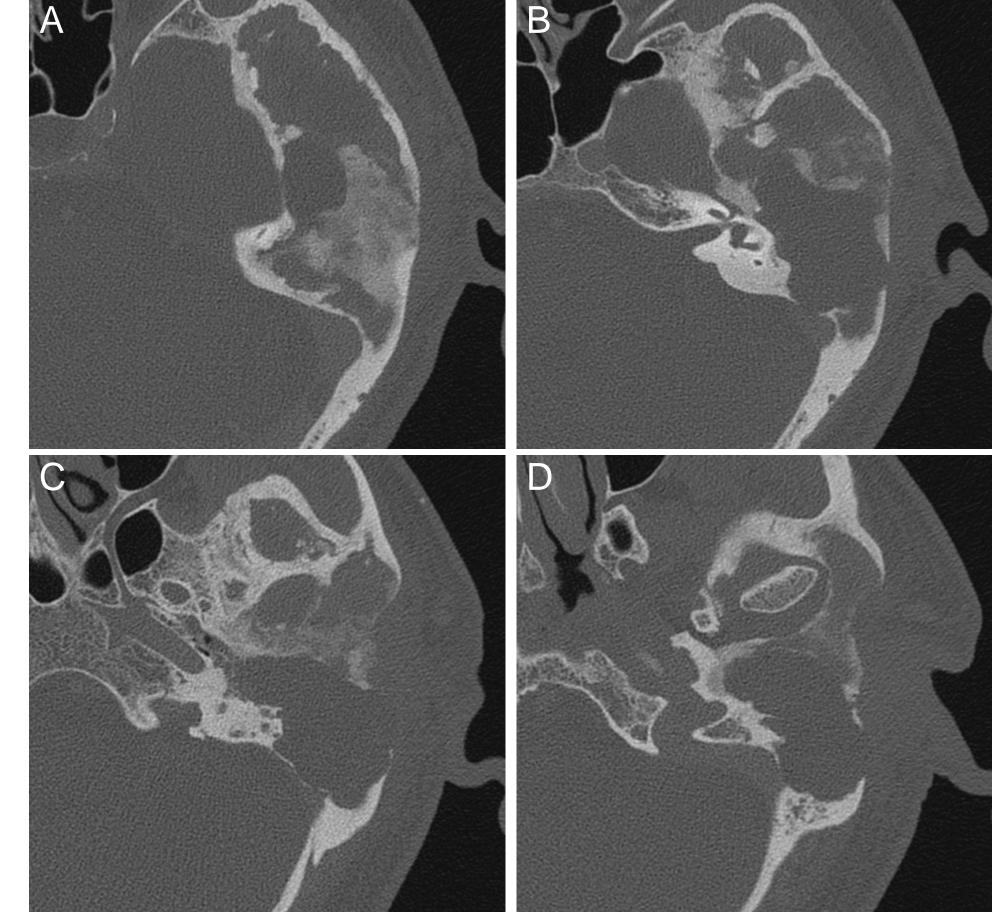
Axial cut images from non-contrast CT scan of the temporal bones at the level of A) dome of superior semicircular canal; B) internal auditory canal; C) carotid canal; and D) temporomandibular joint
